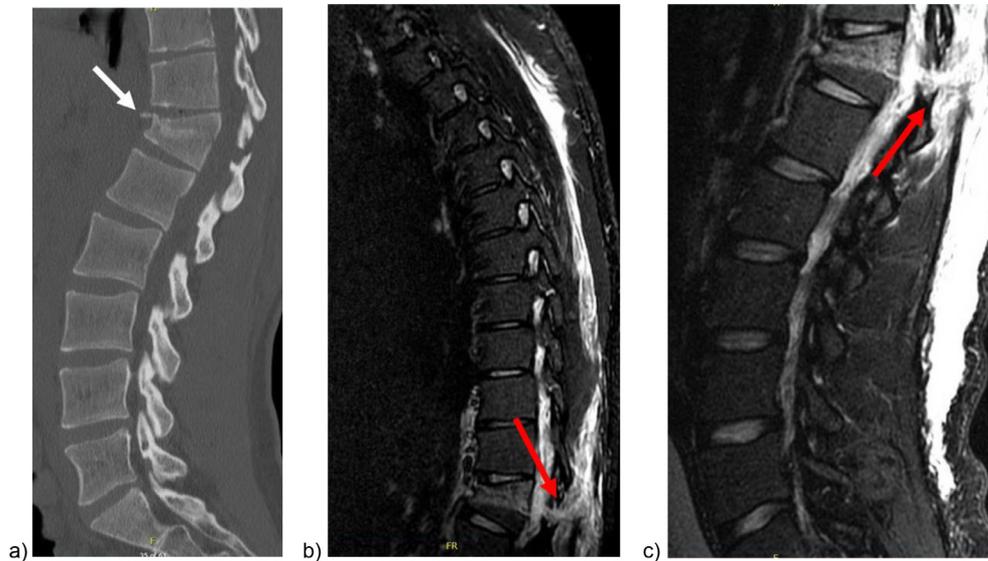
CT (Left) and sagittal STIR MRI of the thoracic (Middle) and lumbar (Right) spine of a patient with a T12 compression fracture diagnosed on CT (white arrow). The fractured T12 vertebra is visualized at the bottom of the thoracic MRI and top of the lumbar MRI, making evaluation of this level cumbersome. In this example, there is a clear injury to the posterior ligamentous complex (PLC) (red arrows), but PLC evaluation in more equivocal cases can be hampered by the need for evaluation of two separate sequences.
